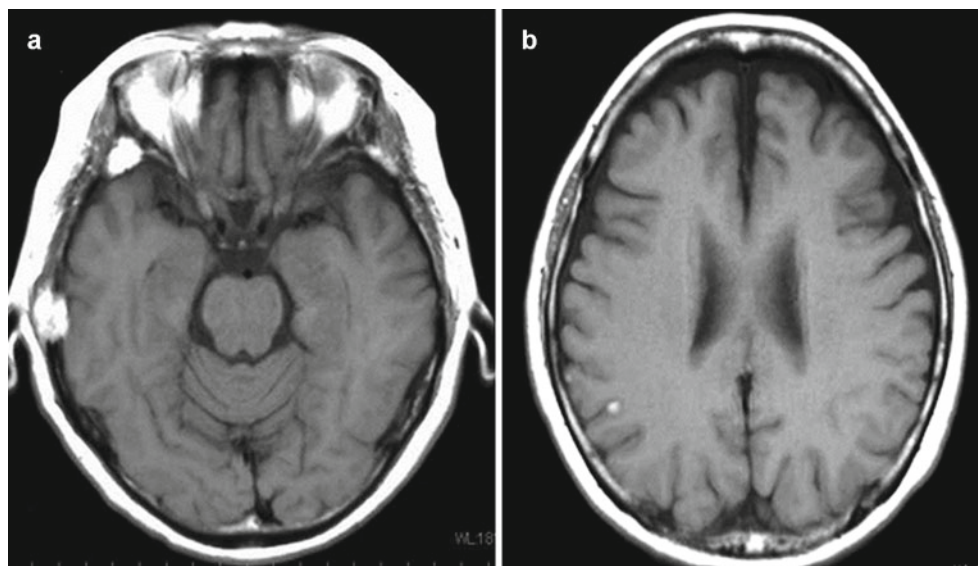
Intracranial metastases of melanoma. Both bone (a) and parenchymal (b) lesions have high signal intensity on precontrast T1-weighted images, reflecting the presence of melanin
